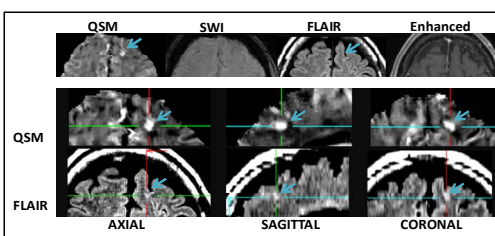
One cortical MS lesion (blue arrows) shown on QSM and FLAIR, not visible on SWI and enhanced MR. The 3-plan view indicates superior conspicuity of QSM compared with FLAIR.
